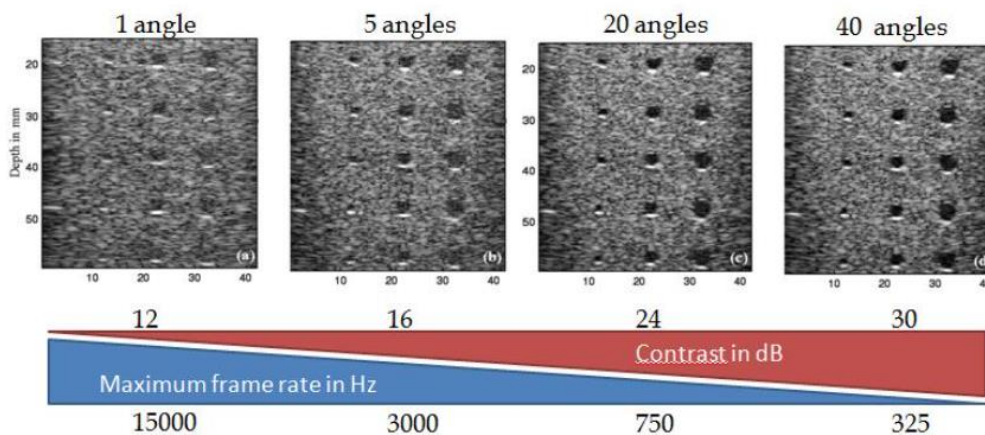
Image quality as a function of the number of angles used to compute the final ultrasound image for a 40mm depth image
